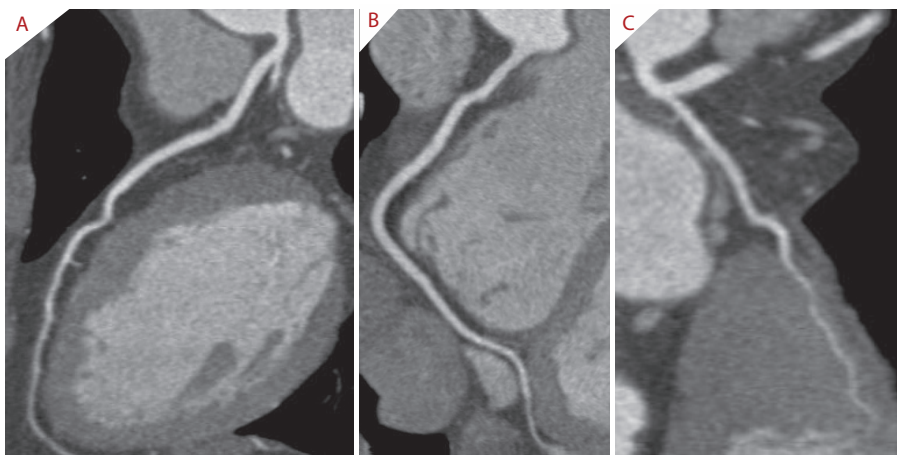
Example of multi-slice computed tomography angiography used to diagnose coronary artery disease. A 64-year-old woman presented to the outpatient clinic for evaluation of atypical chest pain in combination with a positive family history for coronary artery disease. Risk stratification resulted in an intermediate pre-test likelihood for coronary artery disease. Bicycle exercise test was inconclusive and subsequently a multi-slice computed tomography angiography was performed. Curved multiplanar reconstructions of the left anterior descending artery (A), the right coronary artery (B) and the left circumflex coronary artery (C) revealed normal coronary arteries.
